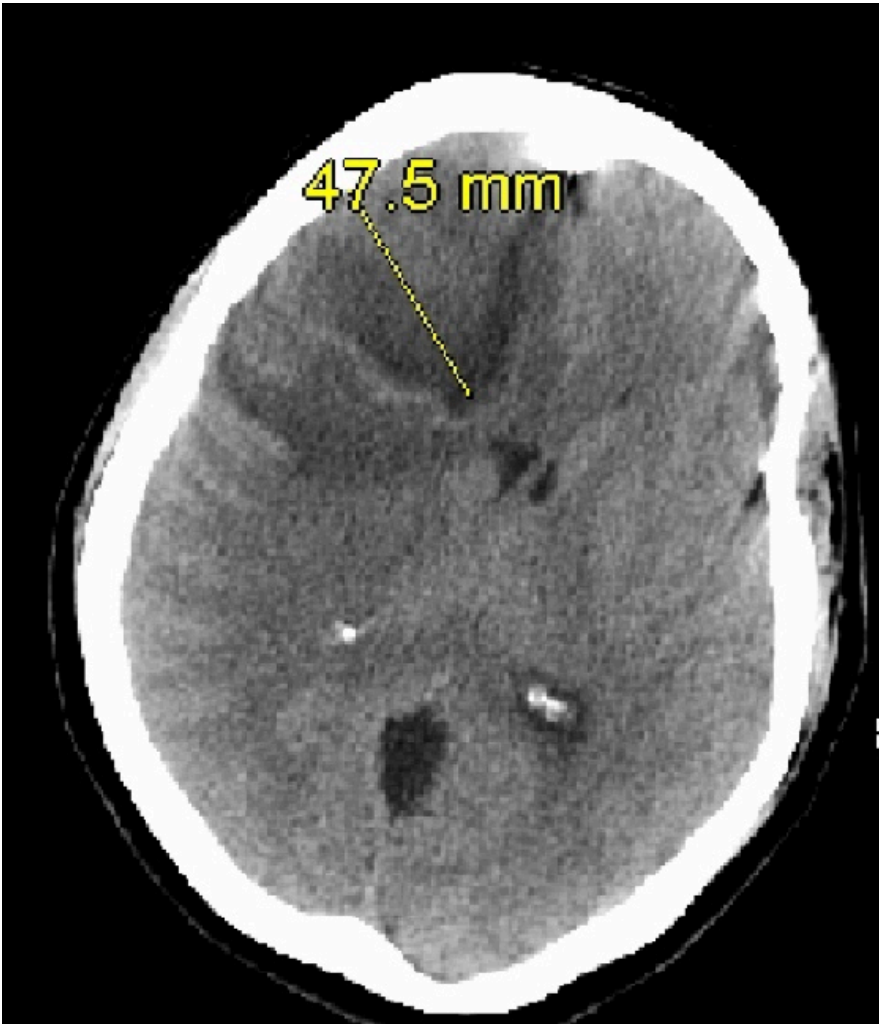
CT of the head without contrast showing a lesion with possible central cystic component measuring up to 4.8 cm in largest diameter.
